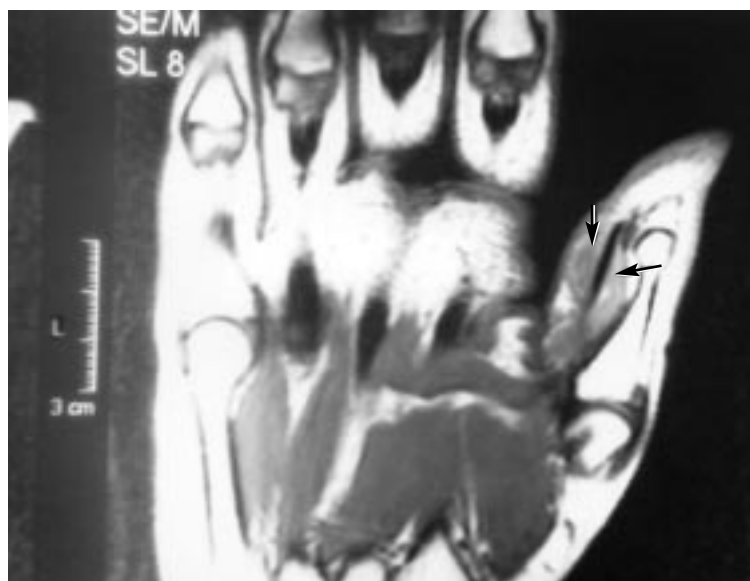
Magnetic resonance imaging scan, coronal section that passes through the midvolar level of the left thumb. Arrows indicate the increased volume in the tenosynovium of the flexor pollicis longus at the proximal phalanx.
